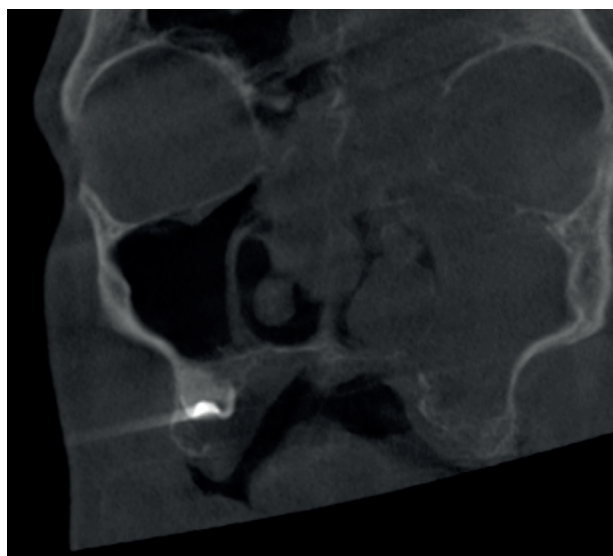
CBCT showing the radiopacity occlusally in the 16
